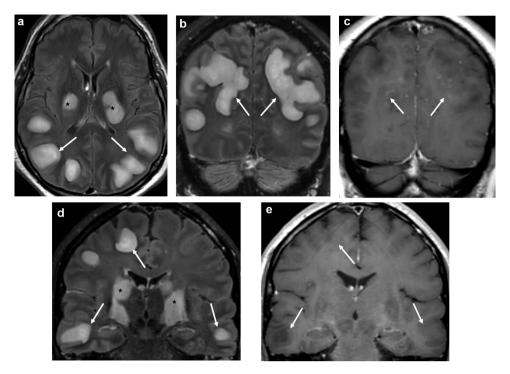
Axial (a) and coronal post-contrast FLAIR (b, d) and coronal T1-weighted (c, e) MR images; (e) multiple nodular hyperintense FLAIR subcortical (arrows) and corticospinal tract (stars) lesions with mild enhancement on T1-weighted MR images (c, e). Abbreviations: MR: magnetic resonance.
